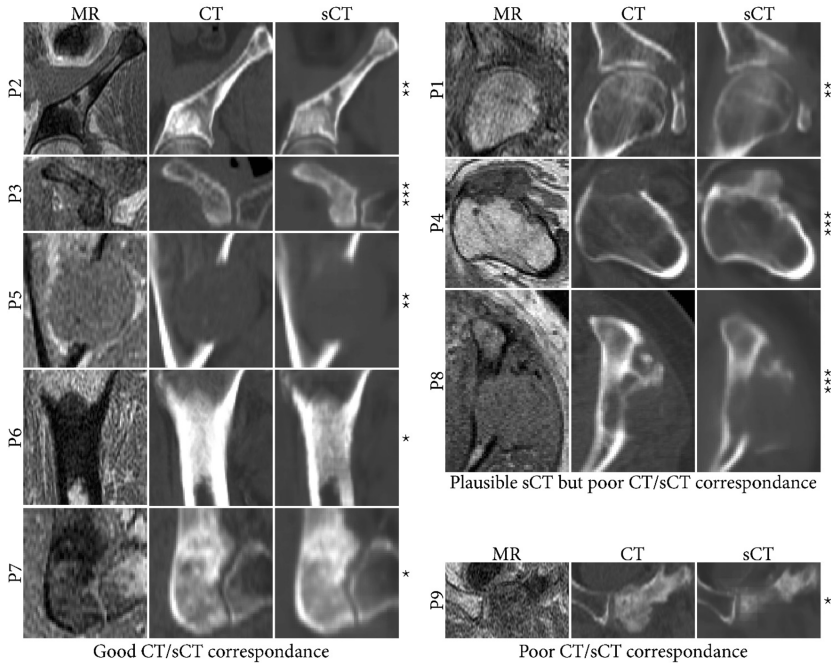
Comparison of single slices out of the MR, CT and sCT datasets of all patients, divided by their sCT-CT correspondance in the lesion. For most patients, lesions could be correctly identified on sCT images. For three patients, differences were observed between CT and sCT images, but it is hard to judge whether they are due to pathological changes (e.g., calcium-enriched bone visible in CT but not MRI in P8) or error in sCT reconstruction. For one patient, definite sCT reconstruction errors are visible with sclerotic regions not well depicted. Stars indicate different timespan between pretreatment CT and treatment MR: * < 10 *days*,  10 – 35 *days*, * > 100 *days*.
